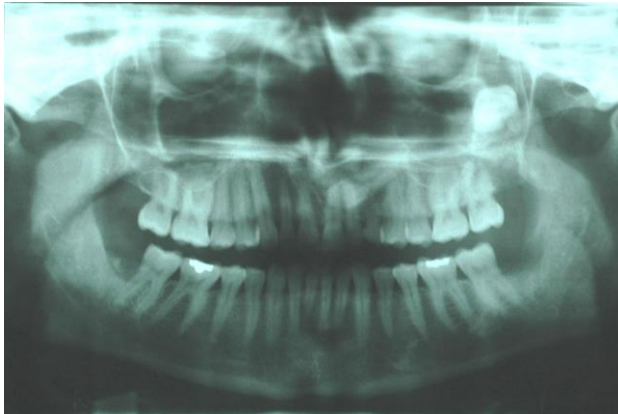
Panoramic radiograph after displacement
